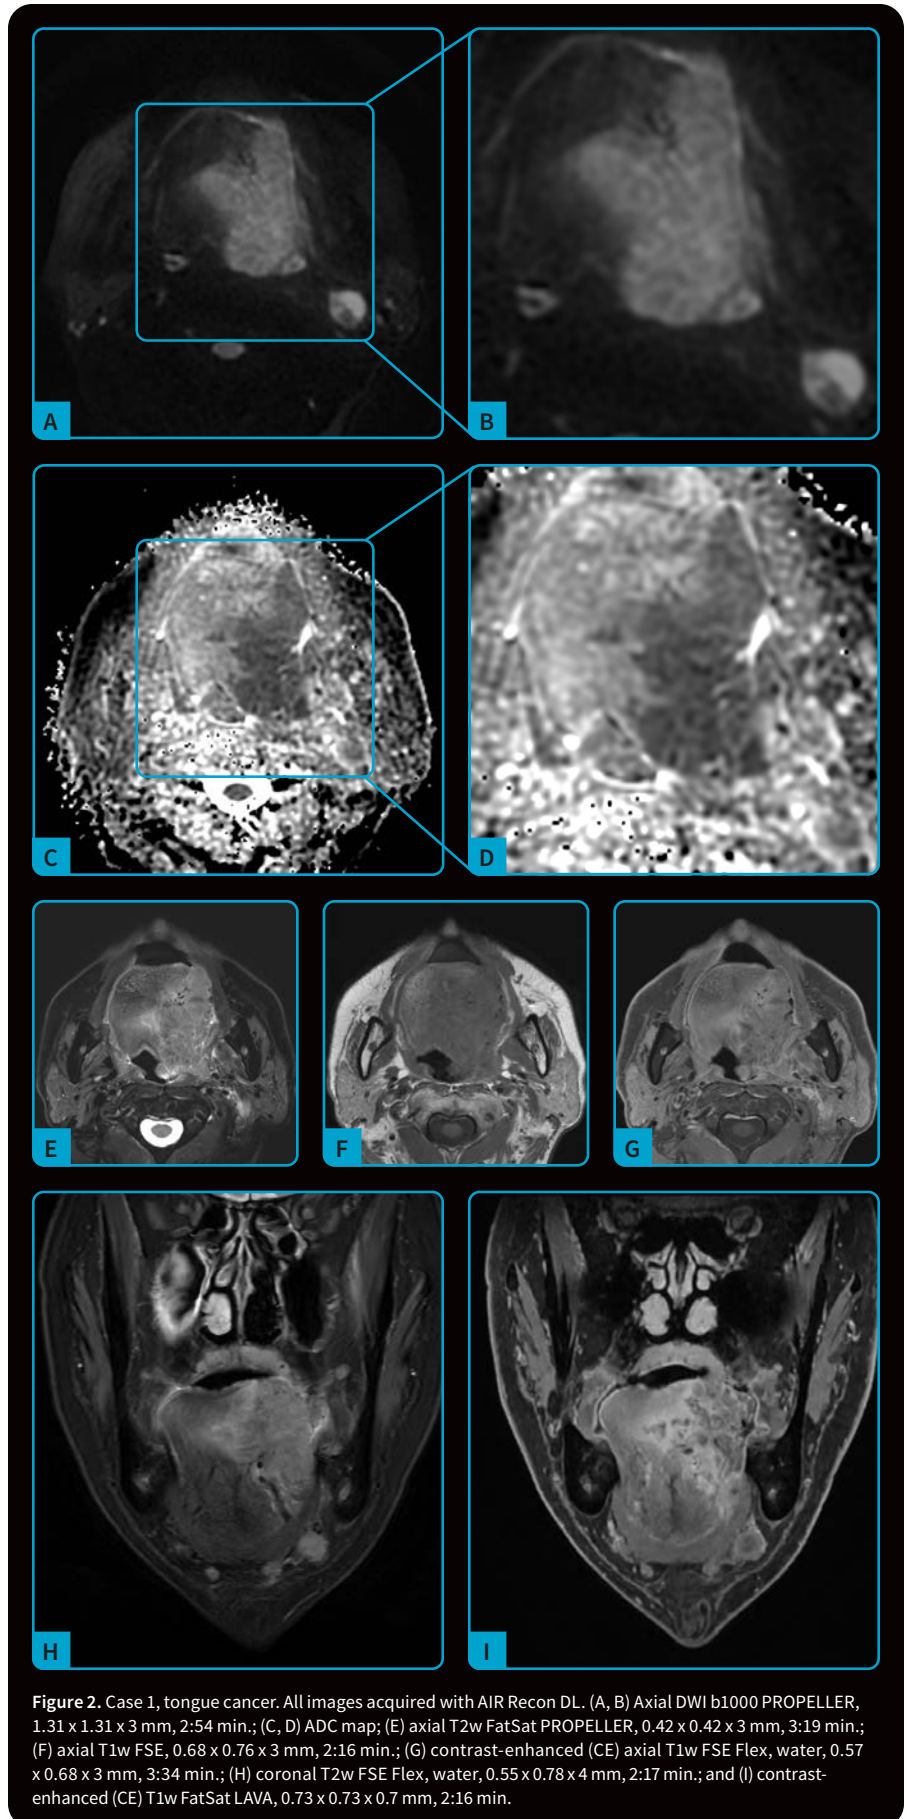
Case 1, tongue cancer. All images acquired with AIR Recon DL. (A, B) Axial DWI b1000 PROPELLER, 1.31 x 1.31 x 3 mm, 2:54 min.; (C, D) ADC map; (E) axial T2w FatSat PROPELLER, 0.42 x 0.42 x 3 mm, 3:19 min.; (F) axial T1w FSE, 0.68 x 0.76 x 3 mm, 2:16 min.; (G) contrast-enhanced (CE) axial T1w FSE Flex, water, 0.57 x 0.68 x 3 mm, 3:34 min.; (H) coronal T2w FSE Flex, water, 0.55 x 0.78 x 4 mm, 2:17 min.; and (I) contrast-enhanced (CE) T1w FatSat LAVA, 0.73 x 0.73 x 0.7 mm, 2:16 min.
